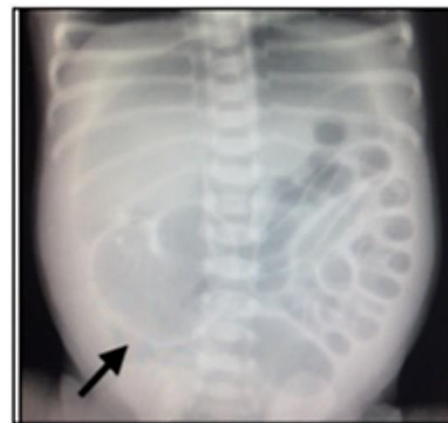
X-ray abdomen AP supine view showing dilated loops and a pneumoperitoneum suggested by football sign. Also, can be seen is a cystic calcified lesion in the right iliac fossa (arrow) suggestive of a meconium pseudocyst.
